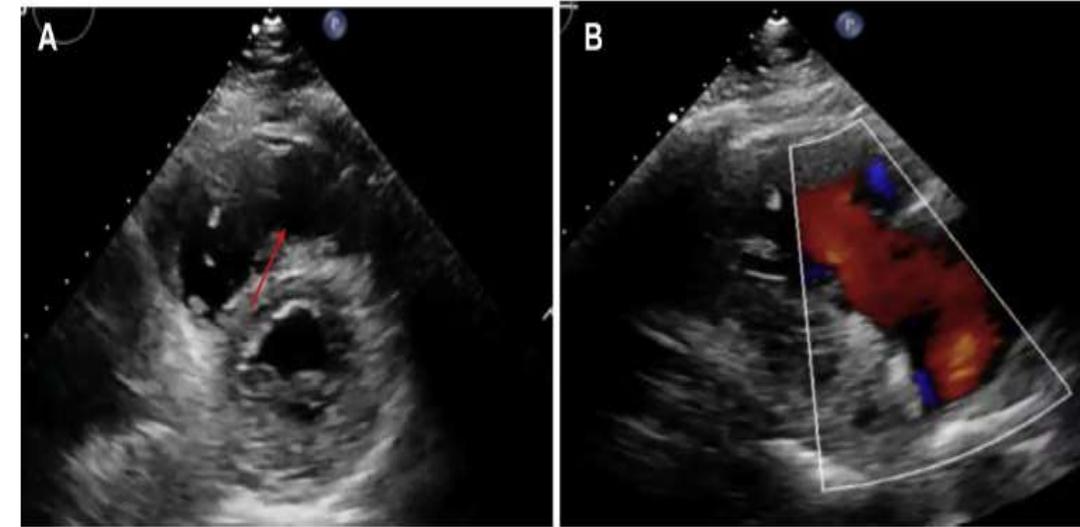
Bedside Transthoracic Echocardiography
